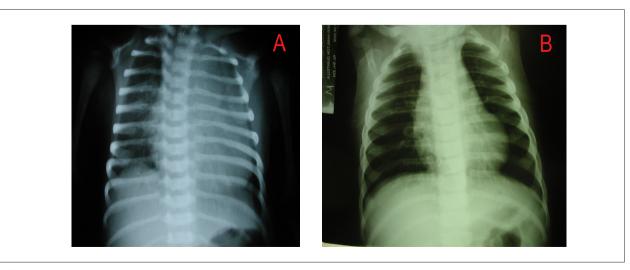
Chest X-rays in the preoperative period in A and nine months after surgery in B highlight the clear difference in heart size.
